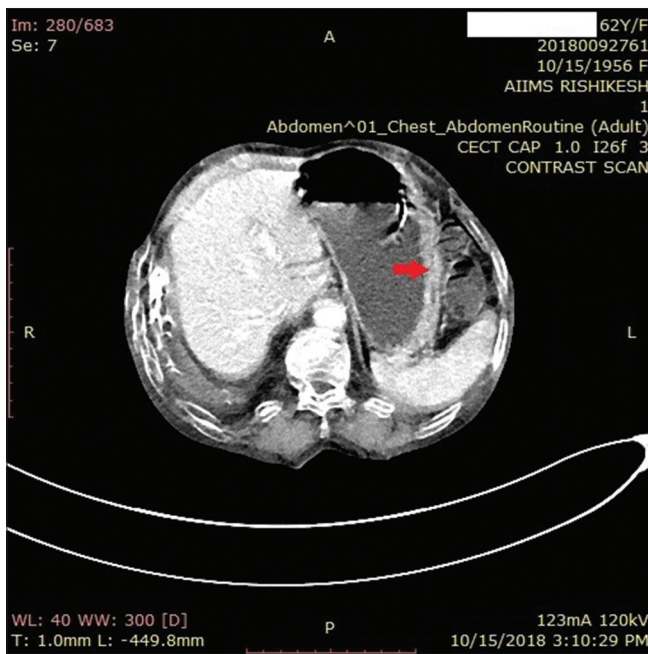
Contrast enhanced computed tomography abdomen showed diffused symmetric circumferential wall thickening involving antrum of the stomach and duodenum with no proximal dilatation
